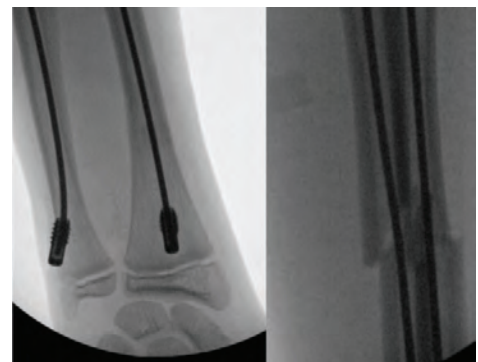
Intraoperative radiographs of radial and ulnar IM nails in appropriate placement across the fracture site (right) and with endcaps (left).
